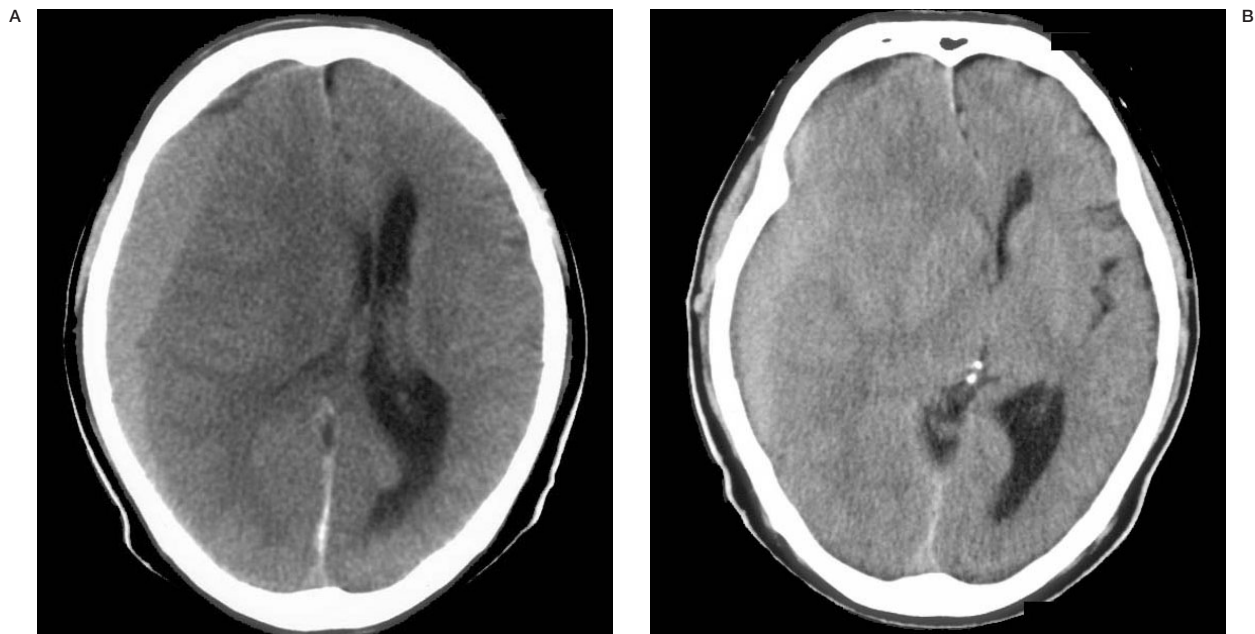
Preoperative (A) and postoperative (B) CT scans in Case 2. A subdural haematoma is noted in the right frontoparietal area with the midline shift, even after the burr hole irrigation surgery.
